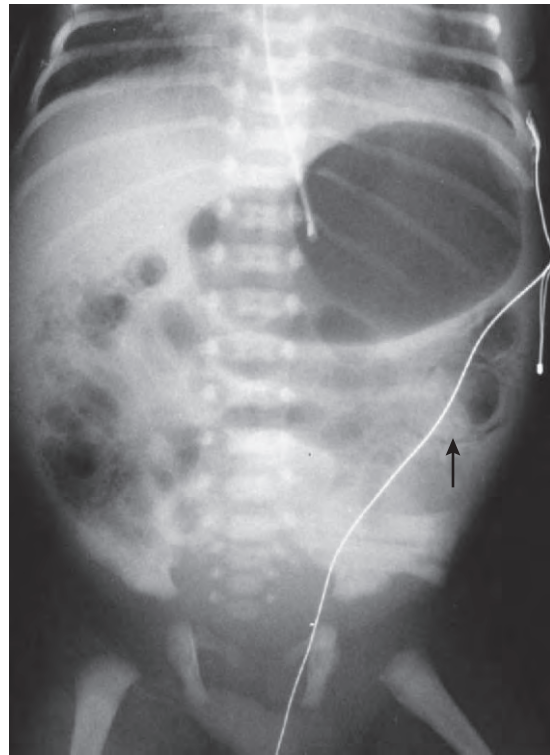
Patterns of intestinal pneumatosis. A supine abdominal radiograph in a neonate with necrotizing enterocolitis demonstrates submucosal (right hemi-abdomen) and linear intramural pneumatosis (*arrow*). (Courtesy of A. B. Campbell, MD, St. Christopher’s Hospital for Children.)
